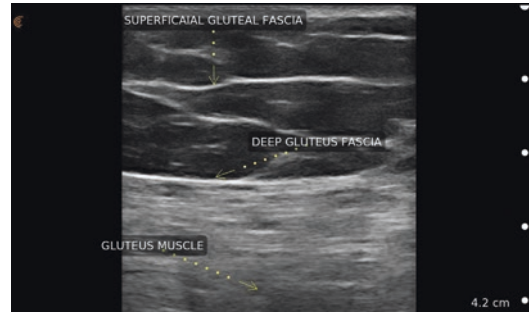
Grayscale ultrasound image of gluteal region. Normal anatomy of buttock showing the subcutaneous space separated by the echogenic superficial gluteal fascia. The deeper echogenic line represents the deep gluteal fascia overlying the gluteal muscle
